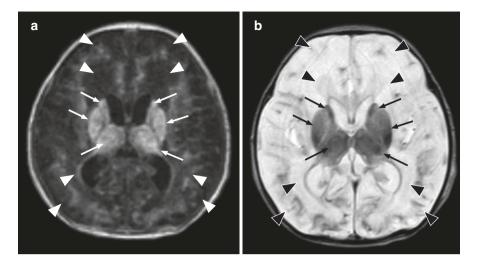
Head MRI image of an infant with basal ganglia and thalamic injury. This is a day 10 postbirth head MRI image of an infant born at 39 weeks of gestation. Apgar scores at 1 and 5 min were 1 and 2, respectively. On admission, the blood pH was 7.00, and the base excess was -26.6 mmol/L. T1-weighted images show hyperintensity of the bilateral caudate nuclei, the lateral part of the putamen, and the thalamus (white arrows). T1-weighted images also show hypointensity of the posterior limb of the internal capsule (white arrowheads). (a) T1-weighted image. (b) T2-weighted image
